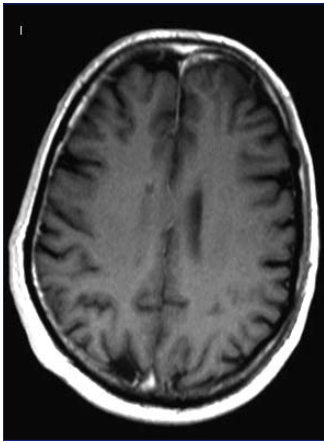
An MRI contrast enhanced T1 weighted image showing interval resolution of most of the tuberculomas except one in the left frontal lobe after 4 months of antituberculous treatment.
